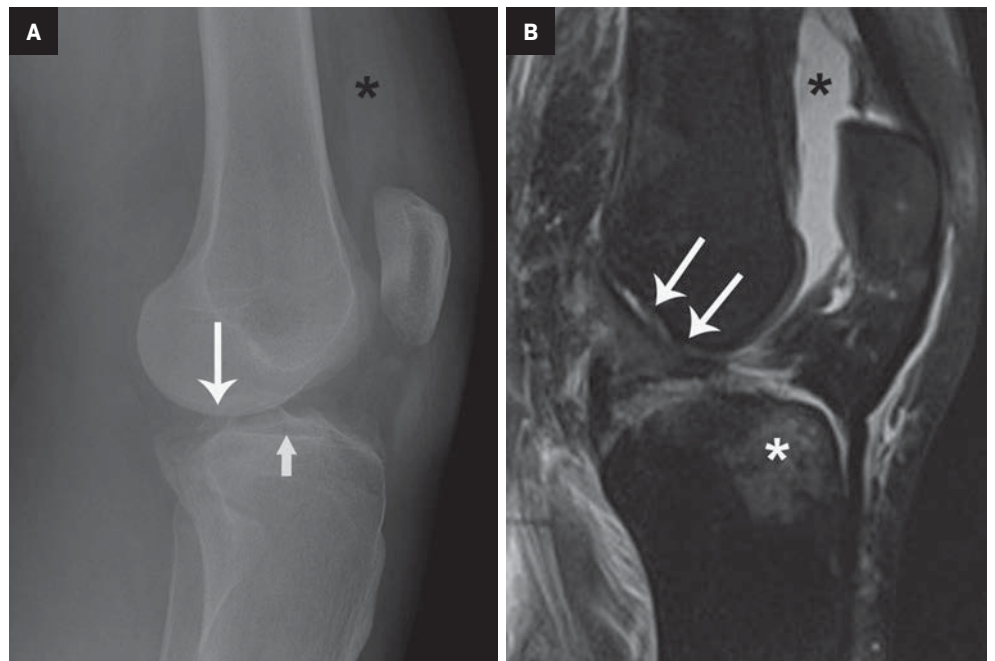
Anterior tibial translation. (A) Lateral radiograph from a pedestrian struck by a car shows a suprapatellar knee effusion (black asterisk). The center of the femoral condyles (long arrow) articulates with the posterior third of the tibial plateau instead of the center (short arrow). (B) Sagittal T2 fat-saturated MR image shows an absence of the anterior cruciate ligament at the intracondylar notch (arrows) compatible with complete tear. An acute bone contusion is present at the tibia (white asterisk).
